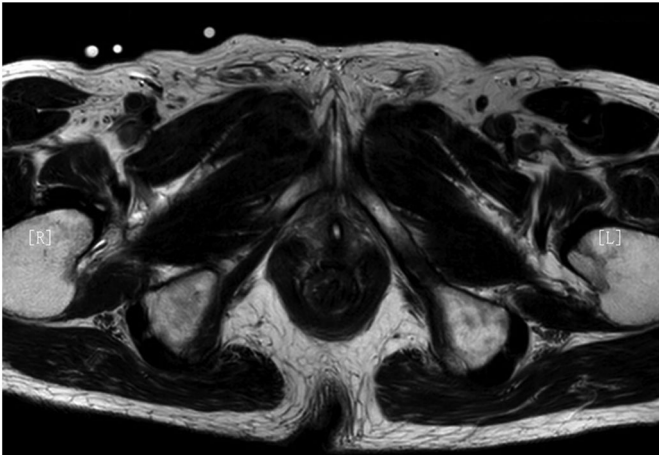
Axial multiplanar turbo spin-echo T2-weighted images. Age = 58 years. PSA = 13.15 ng/mL.
